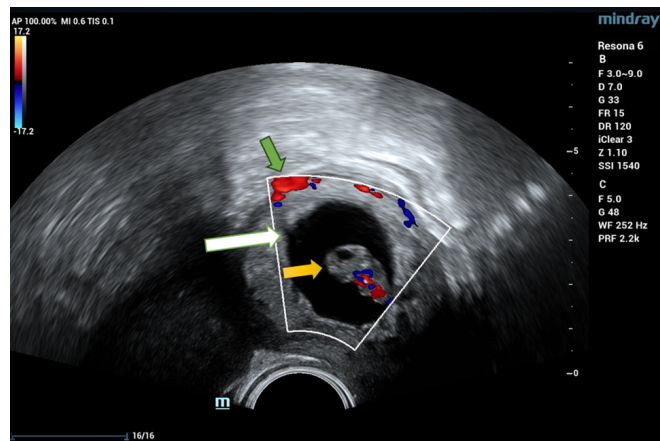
Transvaginal ultrasound with color Doppler demonstrating an intracervical gestational sac (white arrow) containing a pulsating fetal pole (yellow arrow) consistent with 8 weeks of gestation. Peritrophoblastic vascularity (green arrow) is clearly visible on color Doppler imaging, confirming a viable cervical ectopic pregnancy. The gestational sac is located below the level of the internal cervical os, distinguishing this condition from intrauterine pregnancy. Note the characteristic cervical enlargement and the absence of normal uterine cavity implantation.
